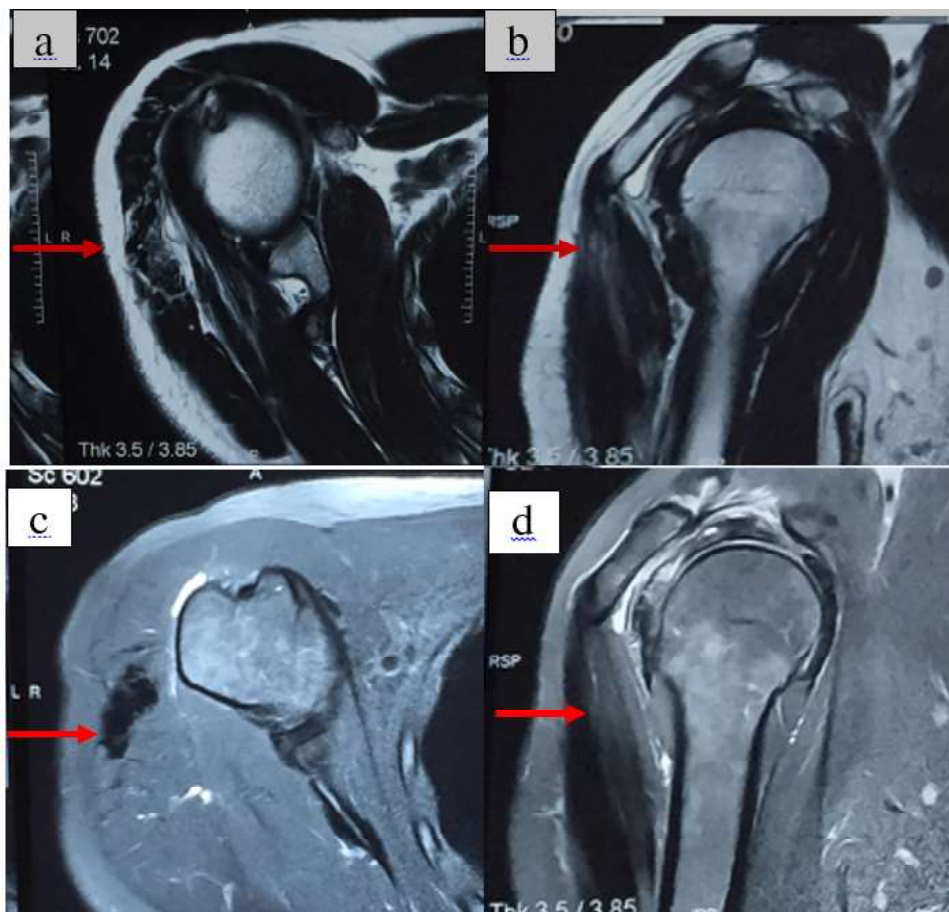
Axial and Coronal MRI sections of the right shoulder showing fibrosis in the deltoid. Note the dimpling of the skin over the fibrosis.
